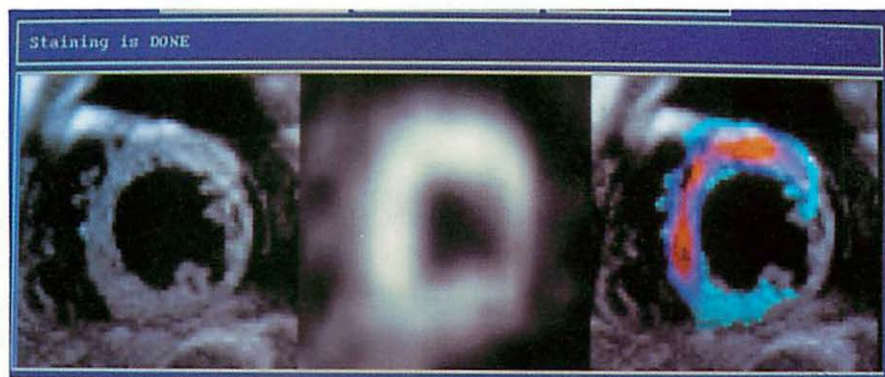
One slice of a cardiac MR image (left). Corresponding slice from the registered SPECT image (center). Fused image combining the MR and SPECT (right).
